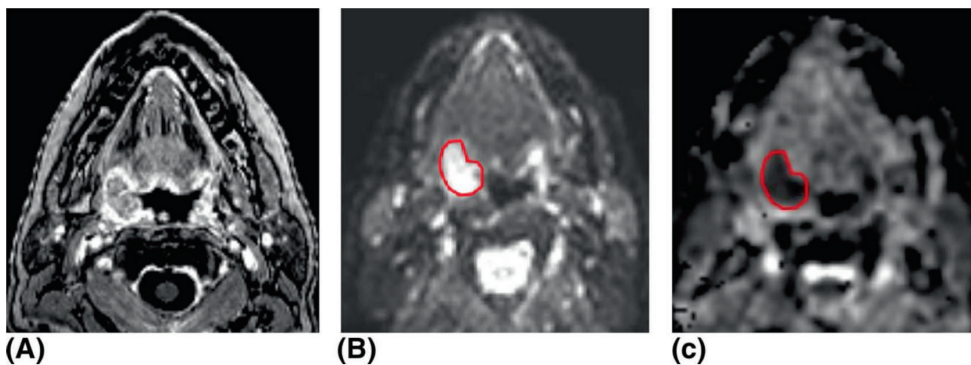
(A–C) Images in a 65-year-old man with a human papillomavirus (HPV)-positive oropharyngeal carcinoma. (A) Axial post contrast T1-weighted MRI with fat suppression shows a right tonsillar mass with limited extension in the glossotonsillar sulcus. (B) Axial diffusion-weighted image ($b = 800 \text{ s/mm}^2$) showing increased signal intensity in the tumor and (C) corresponding axial apparent diffusion coefficient map showing marked signal loss corresponding with a low apparent diffusion coefficient value.
